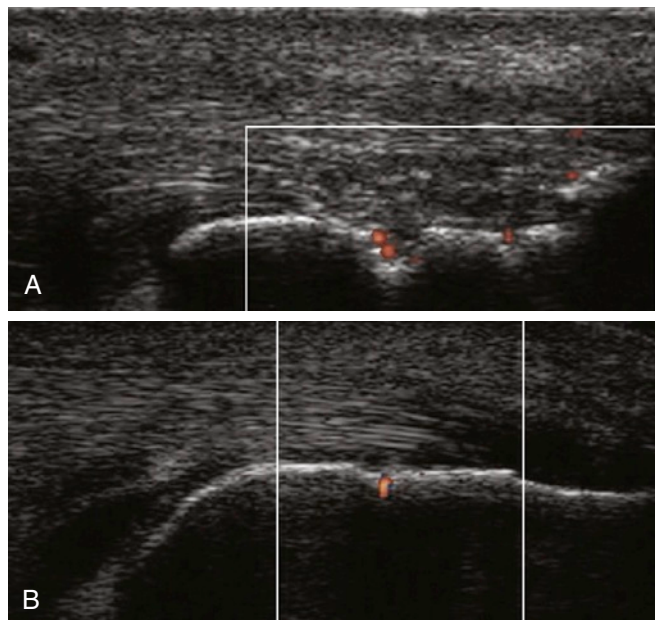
Longitudinal scans show the Doppler signal at the enthesis insertion in a case of Achilles tendon enthesitis that is associated with cortical erosion (A) or no erosion (B).
